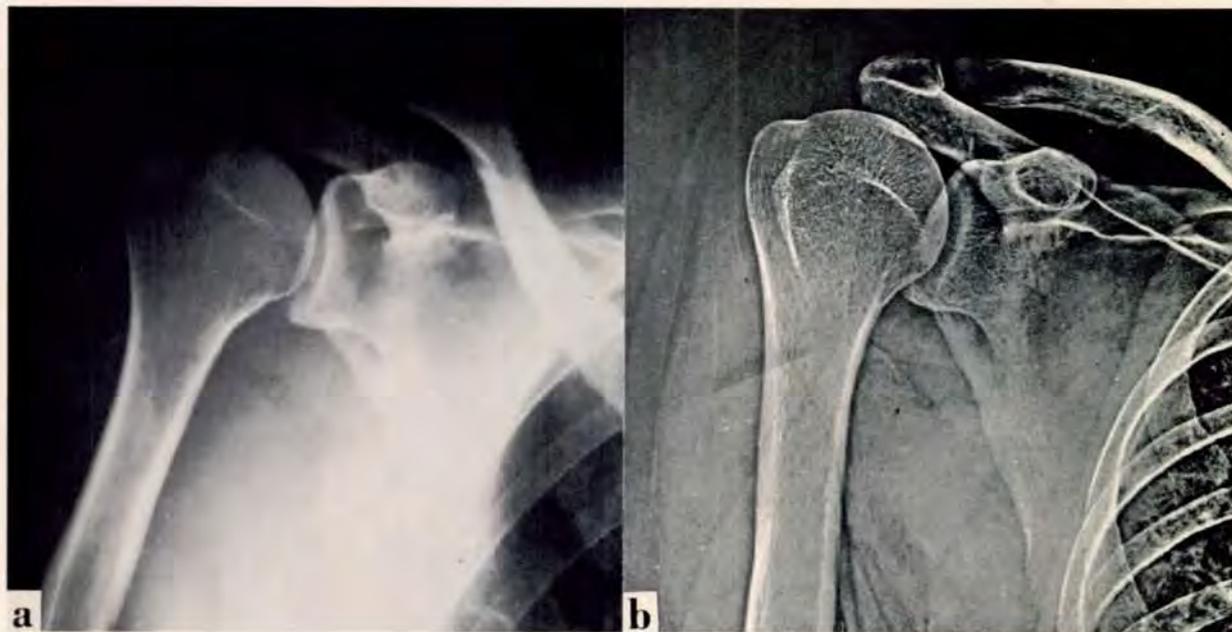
Roentgenographic bone survey of a Gulf of Mexico diver, which proved negative for osteonecrosis. (a) Frontal projection on conventional film of L shoulder, compared with (b) xeroradiogram.
